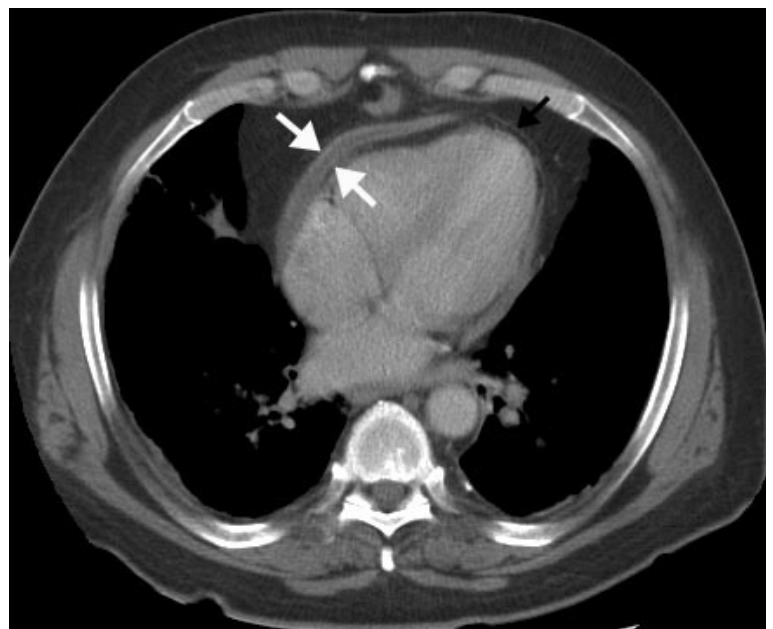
Computed tomogram, showing a pericardium, part of which is of normal thickness (black arrow) and part of which has thickening of both its visceral and parietal components (white arrows) with a trace of fluid between.
